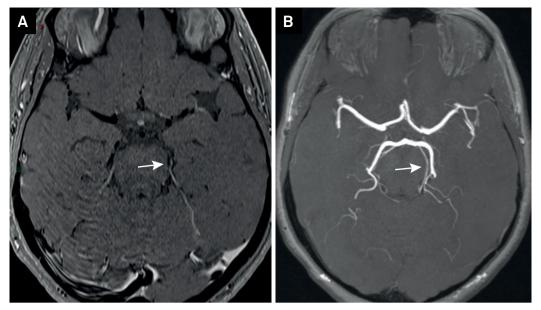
Six-month follow-up. Axial post-contrast brain MRI (vessel wall imaging) shows no enhancement in left superior cerebellar artery (A); axial 3D-TOF MRI angiography shows no artery aneurysm (B).
